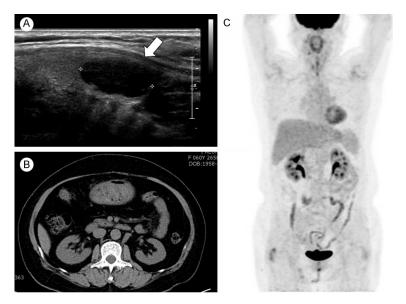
Imaging studies. A. A 1.5-cm low echoic oval mass (arrow) was identified in the left thyroid by ultrasonography. B. There was no suspicious primary lesion in either kidney based on CT scan. C. Torso PET scan also revealed no other primary sites.
